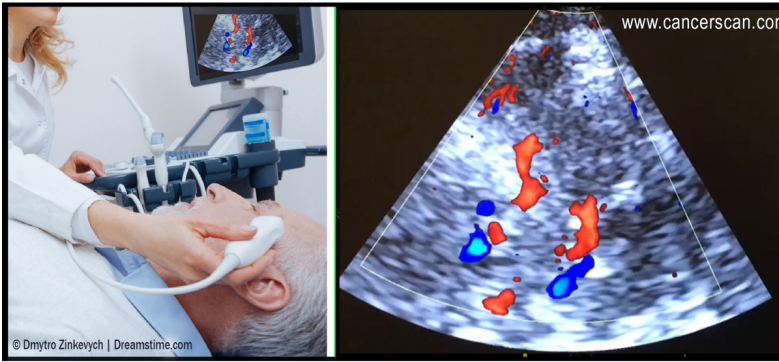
Transcranial ultrasound imaging through the temporal window [26].
